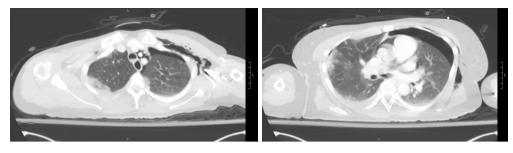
(M96857 CT CAP from 12/26/2019). Extensive subcutaneous emphysema within the neck and anterior chest wall, moderate left pneumothorax, pneumomediastinum, and pneumopericardium. Air-fluid level within the trachea. Respiratory motion artifact limits evaluation of the trachea and esophagus. Esophagogram and bronchoscopy recommended. CT, computed tomography; CAP, chest, abdomen and pelvis.
